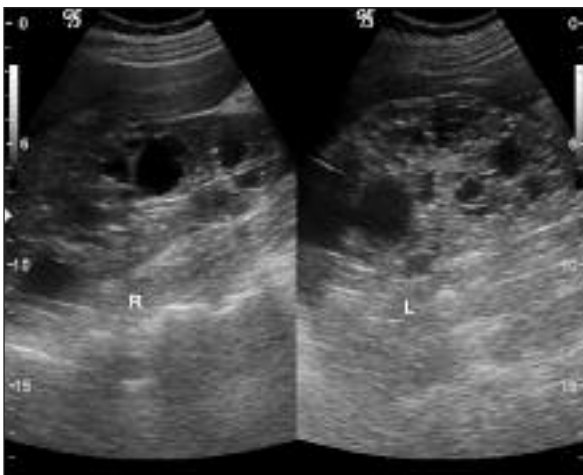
Abdominal ultrasound showed enlarged kidneys including multiple cysts.
